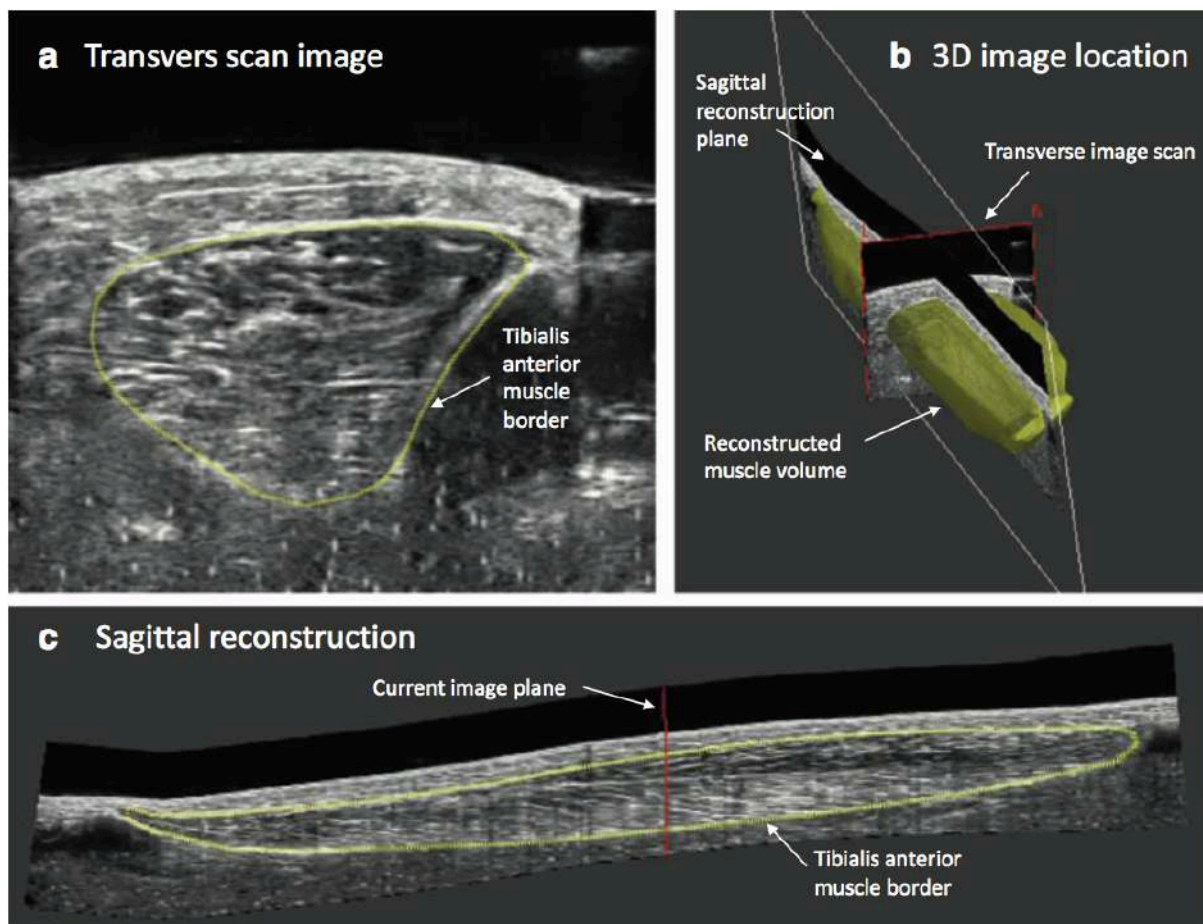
Conventional use of freehand 3D ultrasound. Panel A: transverse scan of the tibialis anterior muscle. Panel B: position of transverse scan relative to muscle and a 3D reconstruction of the muscle volume. Panel C: sagittal plane reconstruction of the muscle. From Lichtwark (2017).
